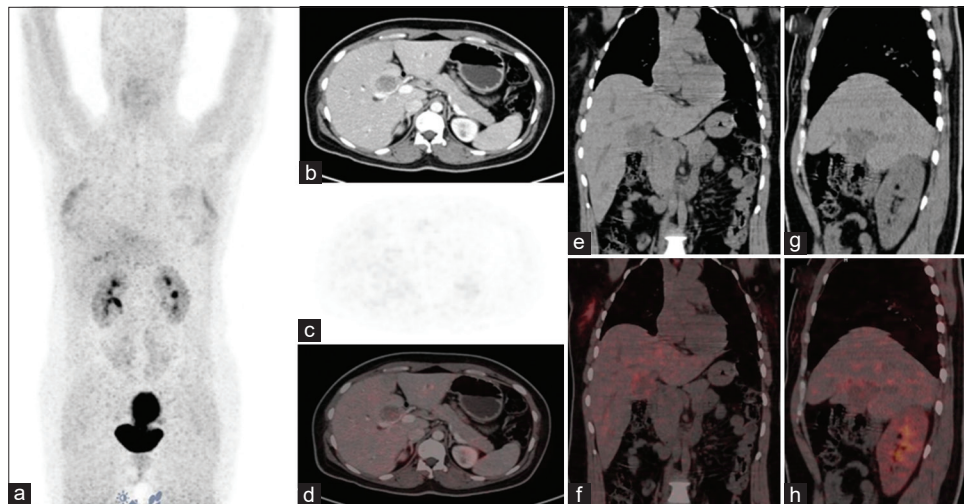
(a-h) Whole body Maximum intensity projection (MIP), corresponding sections of axial, sagittal, and coronal computed tomography (CT) and positron emission tomography-CT images of ^{68}Ga -FAPI-46 showing well-defined hypodense lesion (represented by white solid arrow) at hepatic hilum compressing common hepatic duct with upstream bilateral IHBRD, showing no abnormal increased FAPI expression
